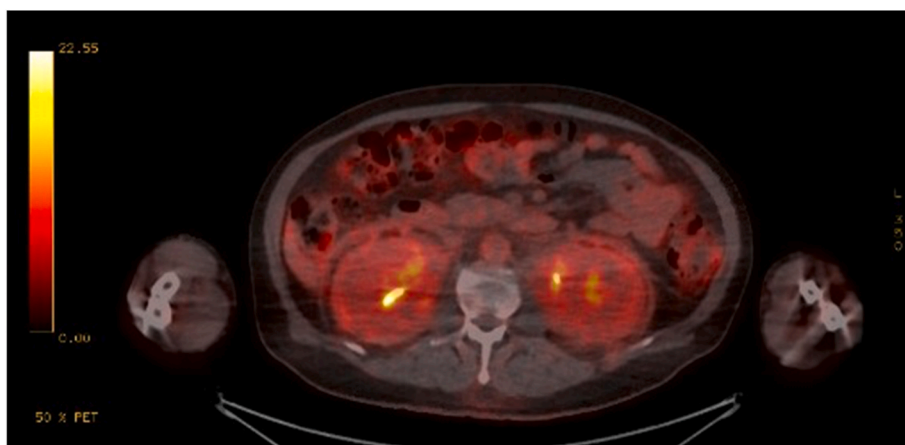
FDG PET CT May 2021. Displaying increased metabolic activity in kidneys bilaterally.
